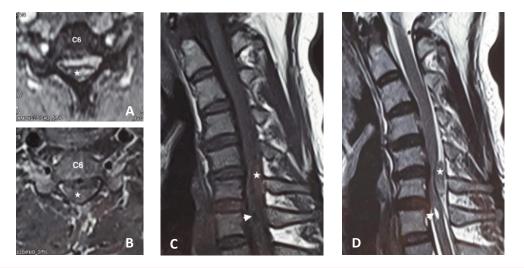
MRI of SSEH showed epidural hematoma at the C5-C6 level (star) and syringomyelia at C7 (head arrow), and revealed heterogeneous hyperintense on T2W image (A, D), homogeneous isointense on T1W image (C), and no enhancement of the SSEH on T1W after Gd administration (B).
